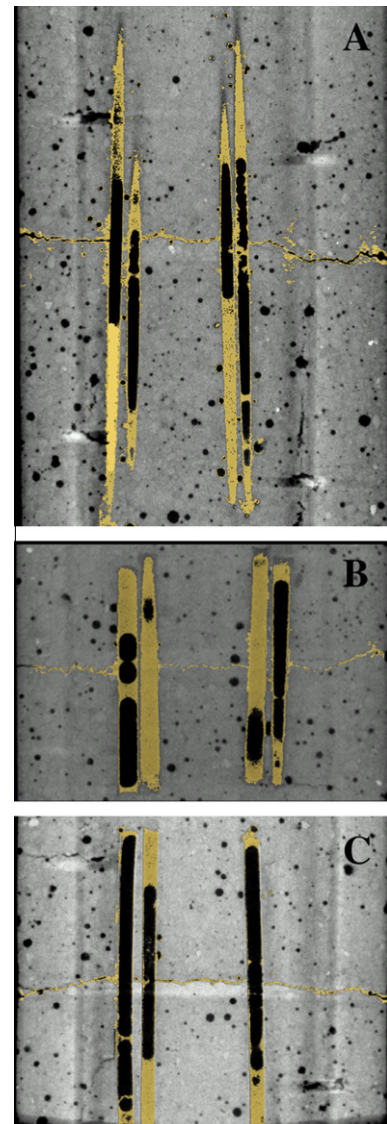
Y-direction CT cross section through the glass tubes, (A) sample with 2 mm diameter glass tubes, (B) sample with 3 mm diameter glass tubes and (C) sample with ceramic tubes.
